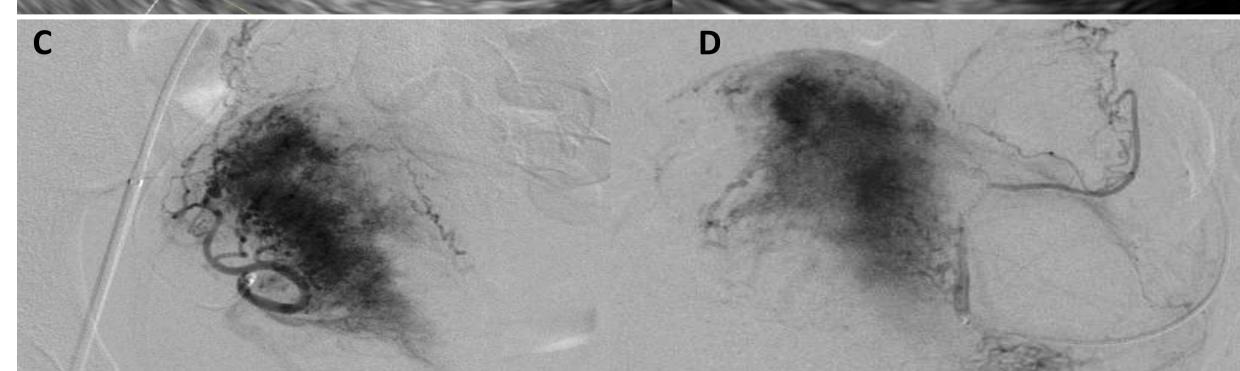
(A-D): 20 yo F presented with vaginal bleeding after medical abortion. Ultrasound (A, B) showed myometrial vascular lesion "concerning for AVM or retained products". Beta-hCG was zero. Uterine artery angiogram (C,D) did not show vascular lesion consistent with SIPB. Bilateral UAE was performed with 500-700 nm microparticles with adequate hemostasis.
